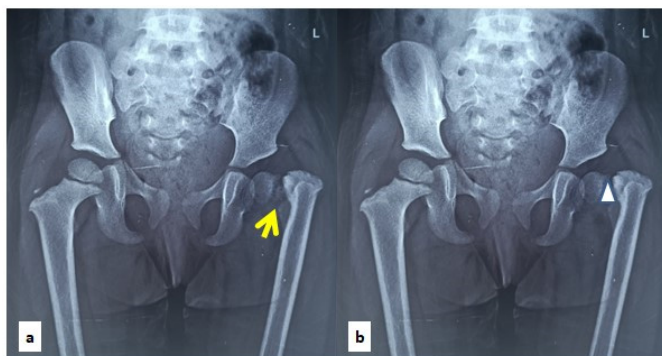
Initial radiographic evaluation of the proximal femoral physis. (a) Anteroposterior pelvis radiograph demonstrating a vertical physis with a distinct triangular radio-lucency at the inferior neck margin is indicated by the arrow. (b) Identical radiographic view with a superimposed triangular overlay highlighting the exact boundaries of the unstable bone fragment.
